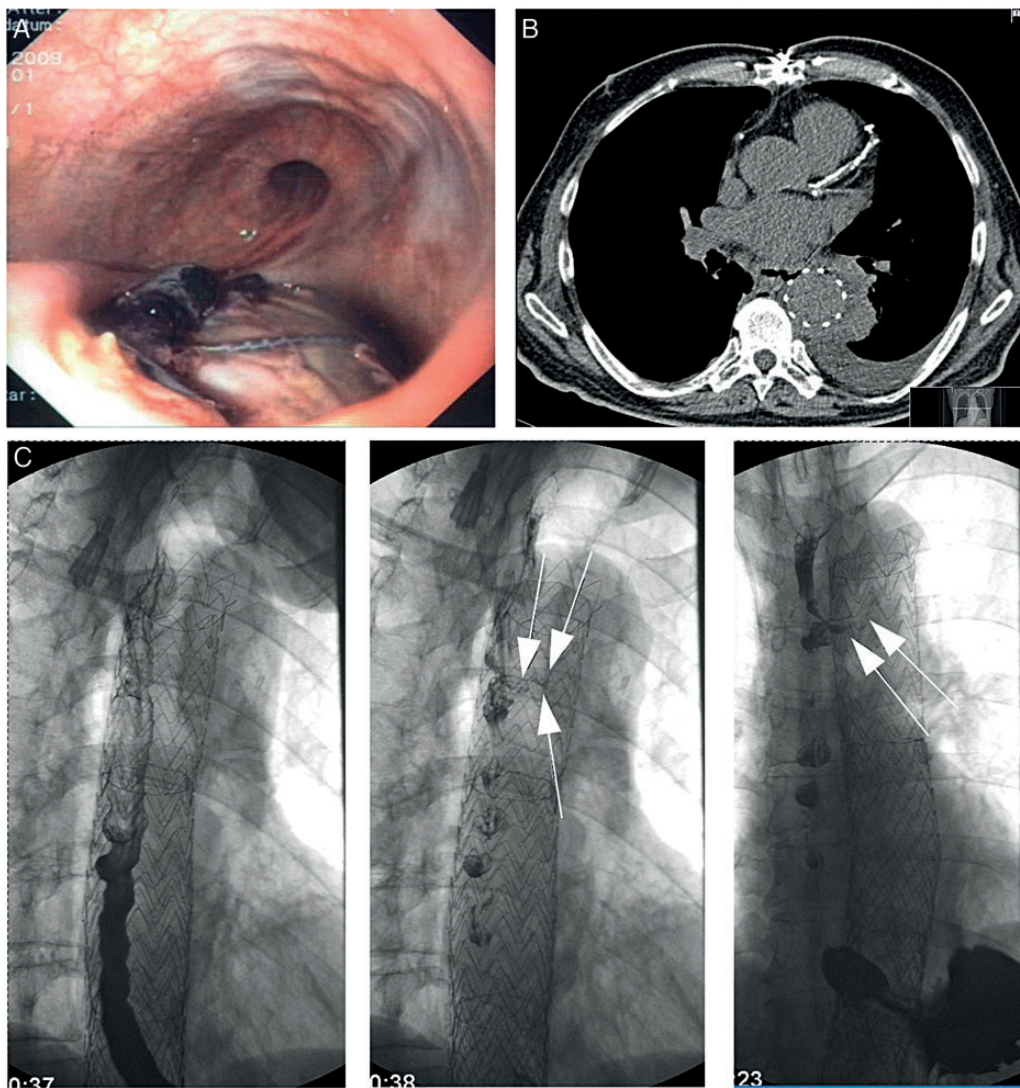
Diagnosis of aorto-oesophageal fistulae by endoscopy (A), computed tomography (B) or oesophagography (white arrows) (C).
